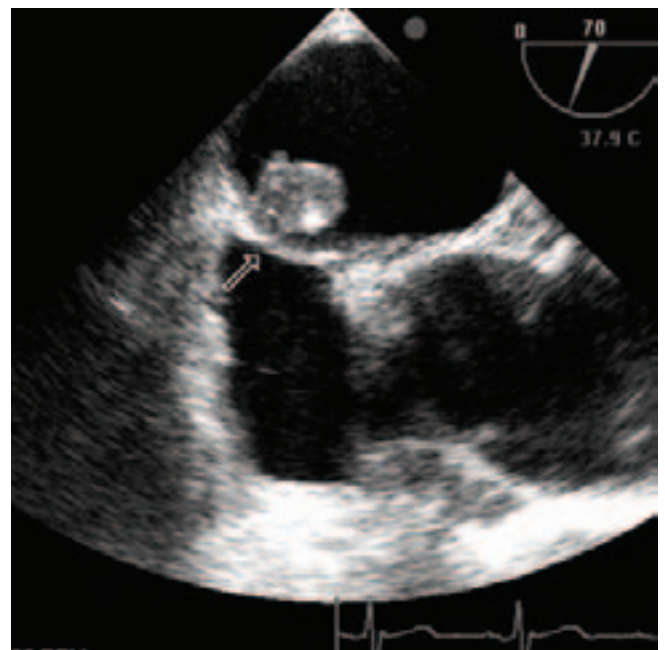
Large left atrial myxoma; transesophageal long-axis view showing the attachment of the tumor to the fossa region (arrow)
